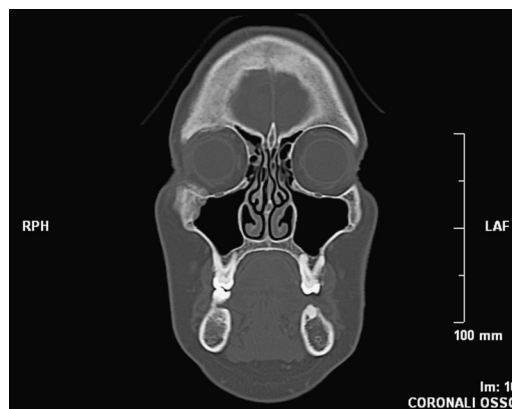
Coronal CT scan demonstrating the right zygomatic lesion, extended to the orbit, the maxillary sinus, and the soft tissue of the cheek.
